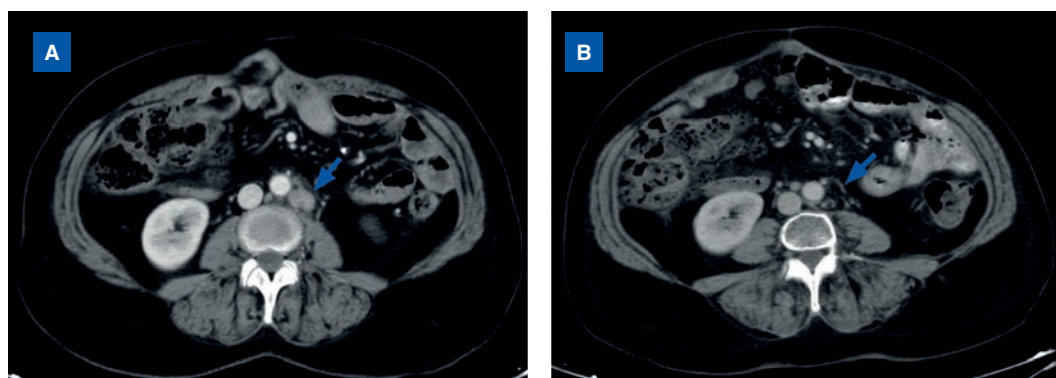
CT scan. A: September 2019: progression at glandular level with multiple lymphadenopathies affecting the middle and lower retroperitoneum. Over 20 lymphadenopathies ranging from 0.8 to 2.2 cm in size were observed (arrow). B: December 2019: absence of lymphadenopathies after five cycles of trabectedin + PLD arrow.
